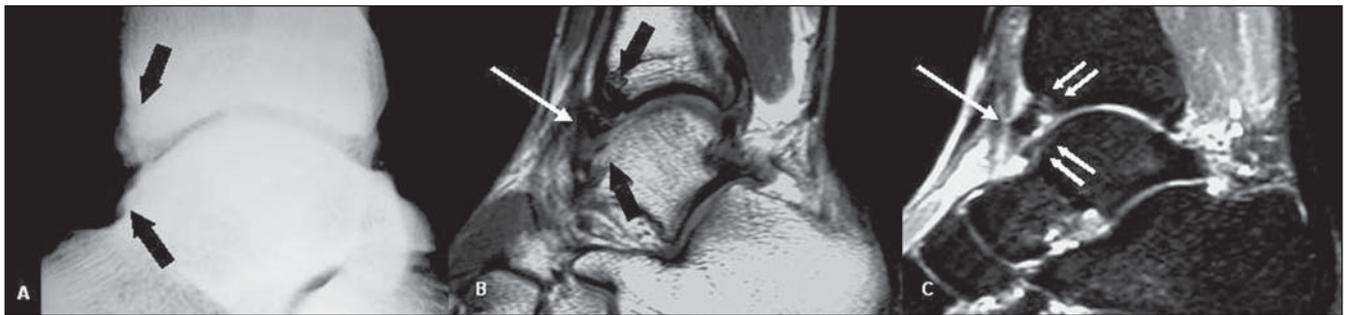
Lateral ankle radiography (A), sagittal T1-weighted (B), and sagittal proton density with fat suppression (C) images demonstrating anterior tibial and talar osteophytes (black arrows) with subtle bone marrow edema (double white arrows), besides anterior capsular thickening (long white arrow) characterizing anterior ankle impingement.
